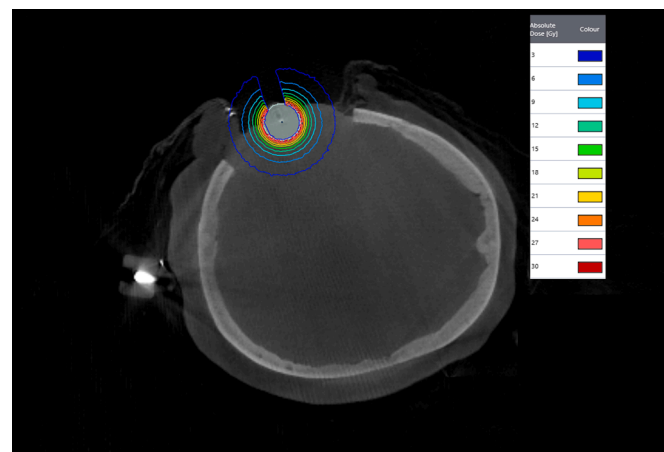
(a) Intraoperative radiotherapy with low-energy (50 kV) X-rays delivers a single-fraction, high-dose radiation treatment to the surface of a spherical polyetherimide applicator, positioned directly into the resection cavity, following gross total resection of a brain metastasis. (b) Exemplary post-hoc calculation of dose distribution within the surgical resection cavity (30 Gy prescribed to the surface of a 2.0-cm applicator), depicting the characteristic steep dose gradient allowing for maximal healthy tissue sparing.
